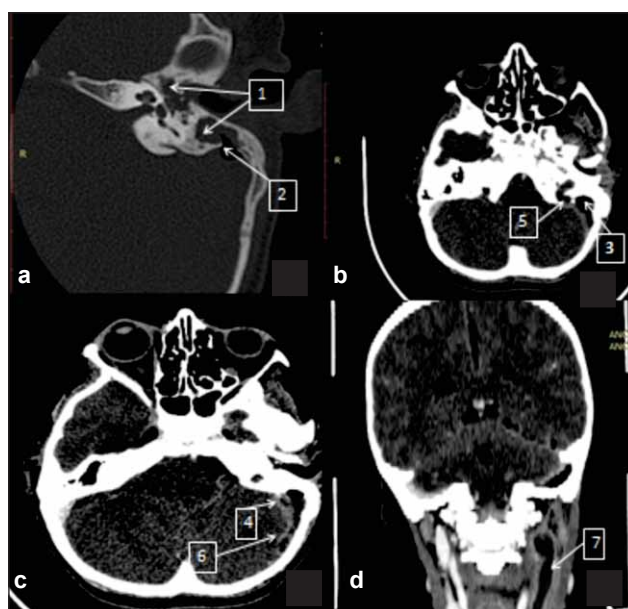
Head and cervical CT
